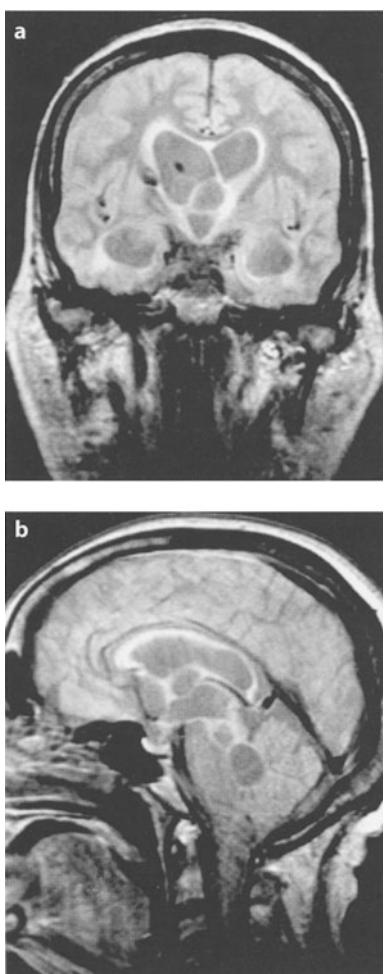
a Coronal and b sagittal FLAIR MRI showing intraventricular cysts and ependymal inflammatory reaction
